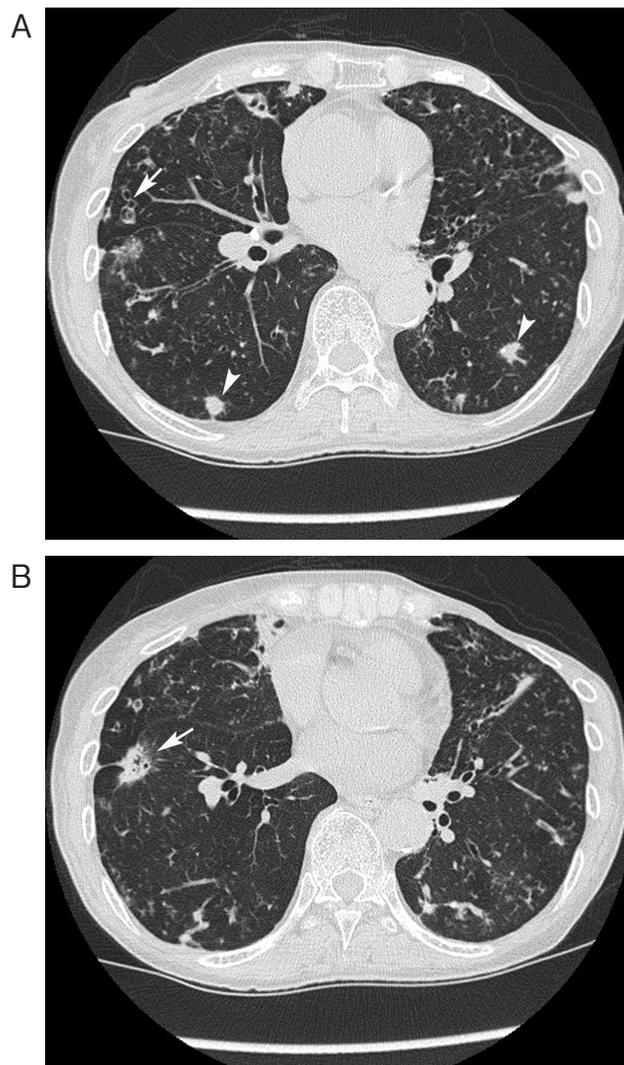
Thoracic CT shows multiple nodular opacities (arrowheads) and bronchiectasis (arrow) (A). Another slice (B) shows spiculated opacity (arrow) in the right S8.
